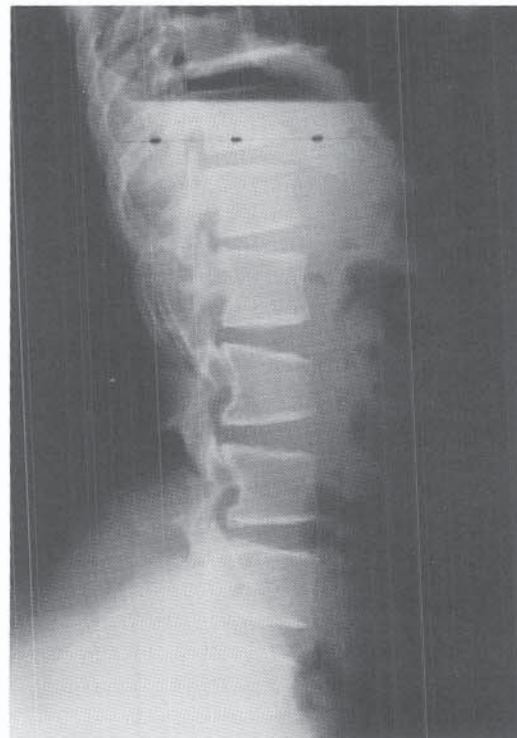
Lateral radiograph of an achondroplastic lumbar spine showing posterior scalloping of the vertebral bodies and shortened pedicles.
